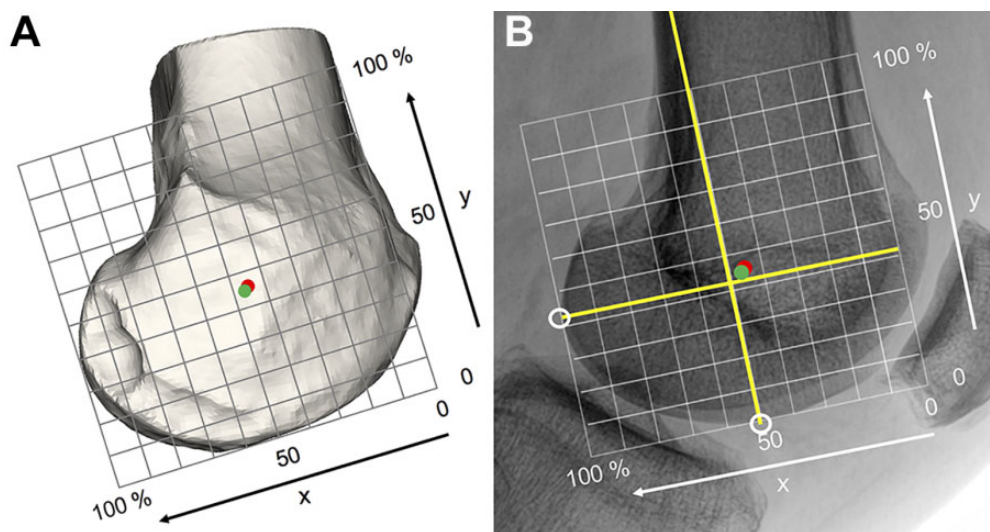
Quantitative radiographic landmarks to identify the most isometric superficial medial collateral ligament (sMCL) insertion point. (A) A close relationship was seen between the most isometric sMCL insertion point (green dot) and the anatomical insertion point (red dot). (B) In a true lateral fluoroscopy view, the most isometric point (green dot) can be identified in direct proximity anterosuperior to the center of a crosshair (yellow lines) that is defined by a line connecting the posterior femoral cortex and most inferior point of the medial condyle (white circle) and a perpendicular line passing through the most posterior point of the medial condyle (white circle). The red dot indicates the anatomical insertion point.
